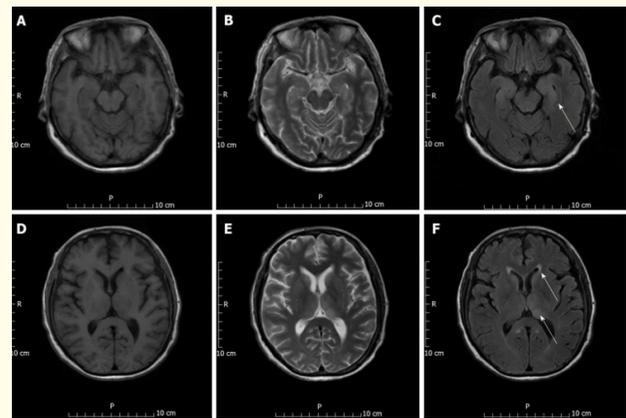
Courtesy ref no-20-Enhanced magnetic resonance imaging scan of the patient's brain on post-transplantation day 19. A, B, D, E: Lesions can be seen in T1 image (A, D) and T2 image (B, E) ; C: Hyperintense lesion is seen in this T2 fluid attenuated inversion recovery image in parahippocampal gyrus; F: Hyperintense lesions are seen in this T2 fluid attenuated inversion recovery image in the bilateral thalamus and caudate nucleus. Arrows indicate the lesions.
